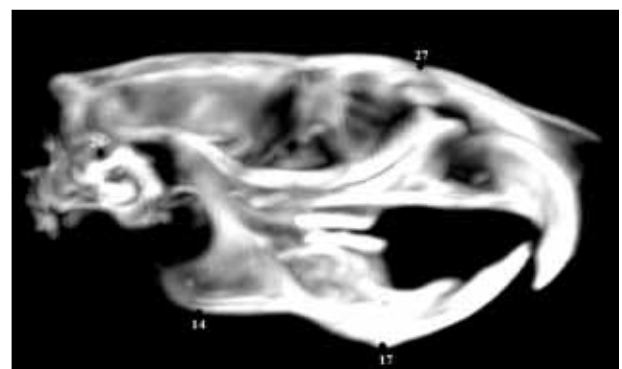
The lateral cephalogram generated from the CT images displaying the anatomical points used for analysis. (see Table I for definitions of all points)
